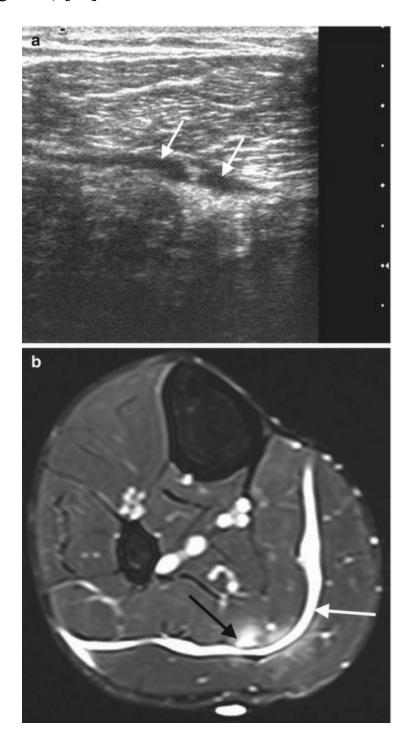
A 26-year-old man with acute right calf pain. Transverse ultrasound image (a) and axial fat-suppressed T2-weighted MRI (b) show musculo-aponeurotic injury of the medial gastrocnemius-soleus muscles complex (*black arrow*) with edema at the musculofascial junction of the soleus and hematoma (*white arrows*)
